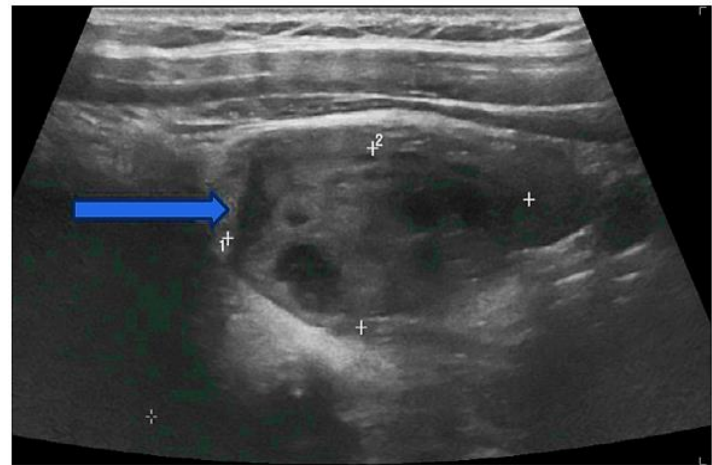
The pointed arrow in the ultrasound of the neck indicates parathyroid adenoma
